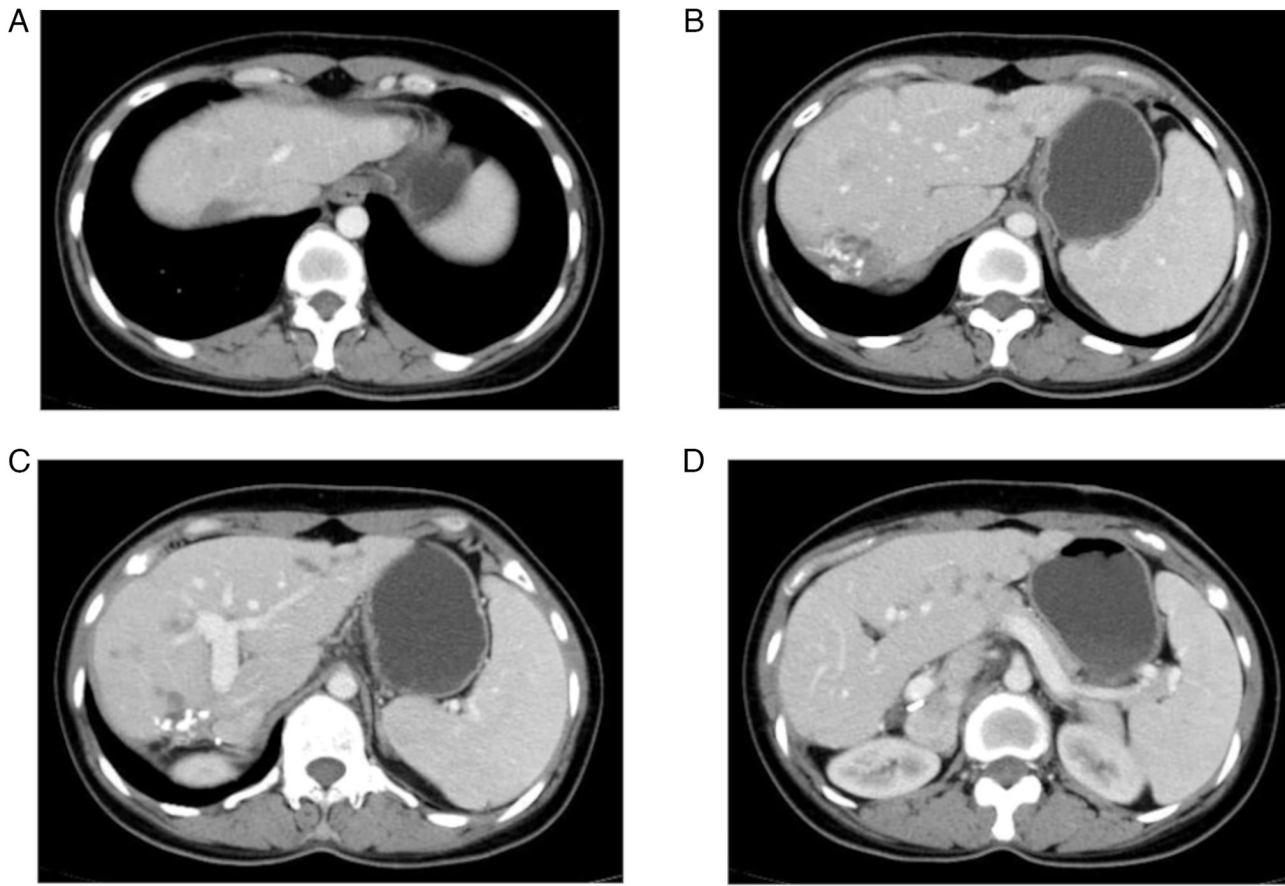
Portal venous phase of contrast-enhanced CT. A few metastases (low signal intensity) are visible in the hepatic parenchyma. The lesions significantly decreased in number and size six months after the time-point of Fig. 3. (A) The largest one is located in the dome of the right hepatic lobe (red arrow) and measures ~1.7 cm in diameter. (B) Hepatic segment SII showed the presence of multiple minimal metastases. (C) The imaging revealed the existence of minor metastases in hepatic segments SII, SV and SVIII. (D) Both hepatic segment SII and SIII exhibited the presence of small metastases.
